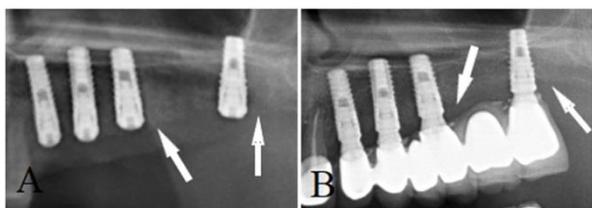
A. Post-operative radiographic image of a patient with fixed prosthesis. B. Radiographic image of the patient during the follow-up period. Minimal marginal bone loss around the implants (white arrow).
